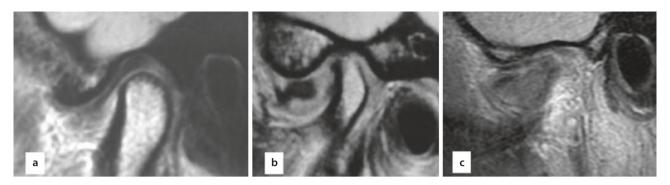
MRI imaging of TMJs. a Normal condyle and disc in fossa. b TMJ arthritis and anteriorly displaced articular disc that is significantly deformed. c TMJ with juvenile idiopathic arthritis
